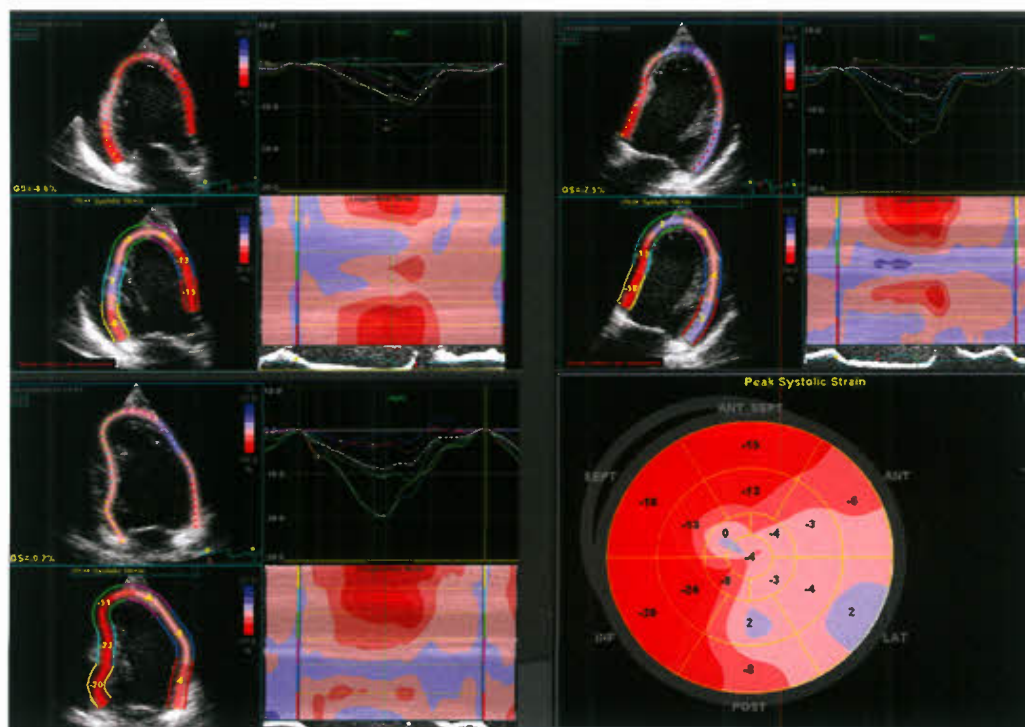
Longitudinal LV strain in a 13-year-old girl who developed a myocardial infarction based on abnormal origin of the left coronary artery from the right cusp with posterior looping and intramural course. The left upper panel represents the strain curves obtained from the apical three-chamber view, the left lower panel represents the strain curves obtained from the apical two-chamber view, and the right upper panel represents the strain curves from the apical four-chamber view. Longitudinal strain measurements are significantly reduced in the inferolateral wall segments (*light pink and blue areas*). The figure on the lower right demonstrates the recommended method for displaying strain data with all 17 cardiac segments portrayed in a bull's-eye type format. This allows an objective quantification of regional myocardial function. In this patient, the *light pink and blue areas* in the inferolateral wall segments represent the extent of the myocardial infarction on regional myocardial function.
